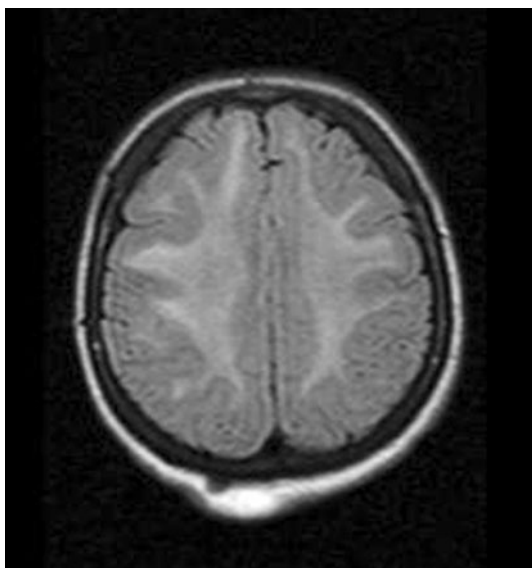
Cranial MRI with white-matter lesion on T2-weighted image (section2)
